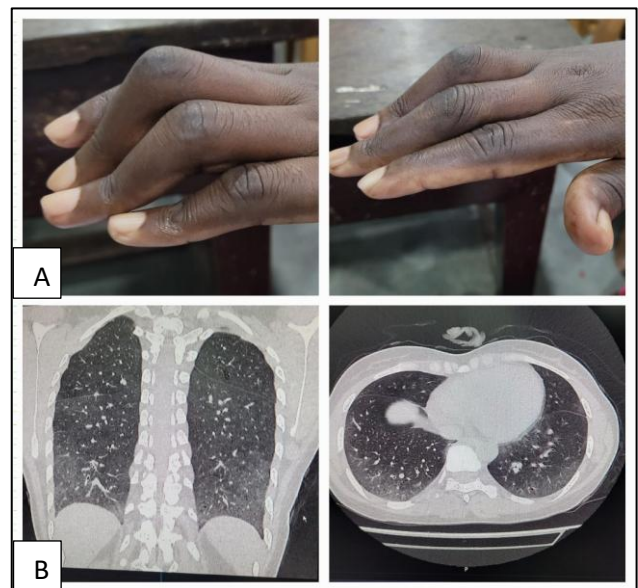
(A and B): Skin tightness with Boutonniere's deformity (top); bilateral basal ground-glass opacification with nodular opacities on HRCT thorax suggestive of interstitial lung disease (bottom).
